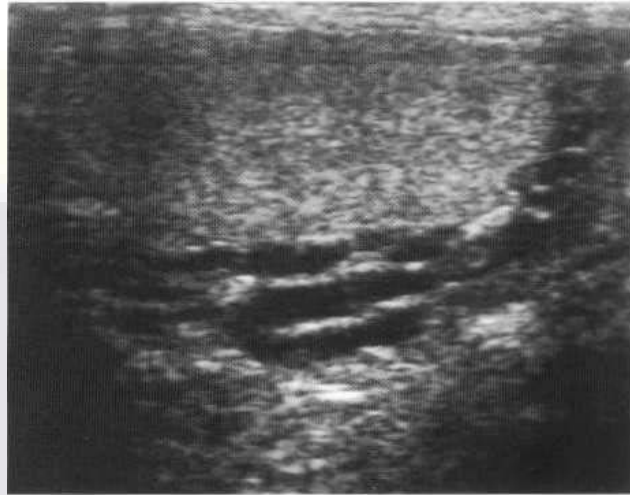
Ultrasound of varicocele seen as echo-free serpiginous structures.
